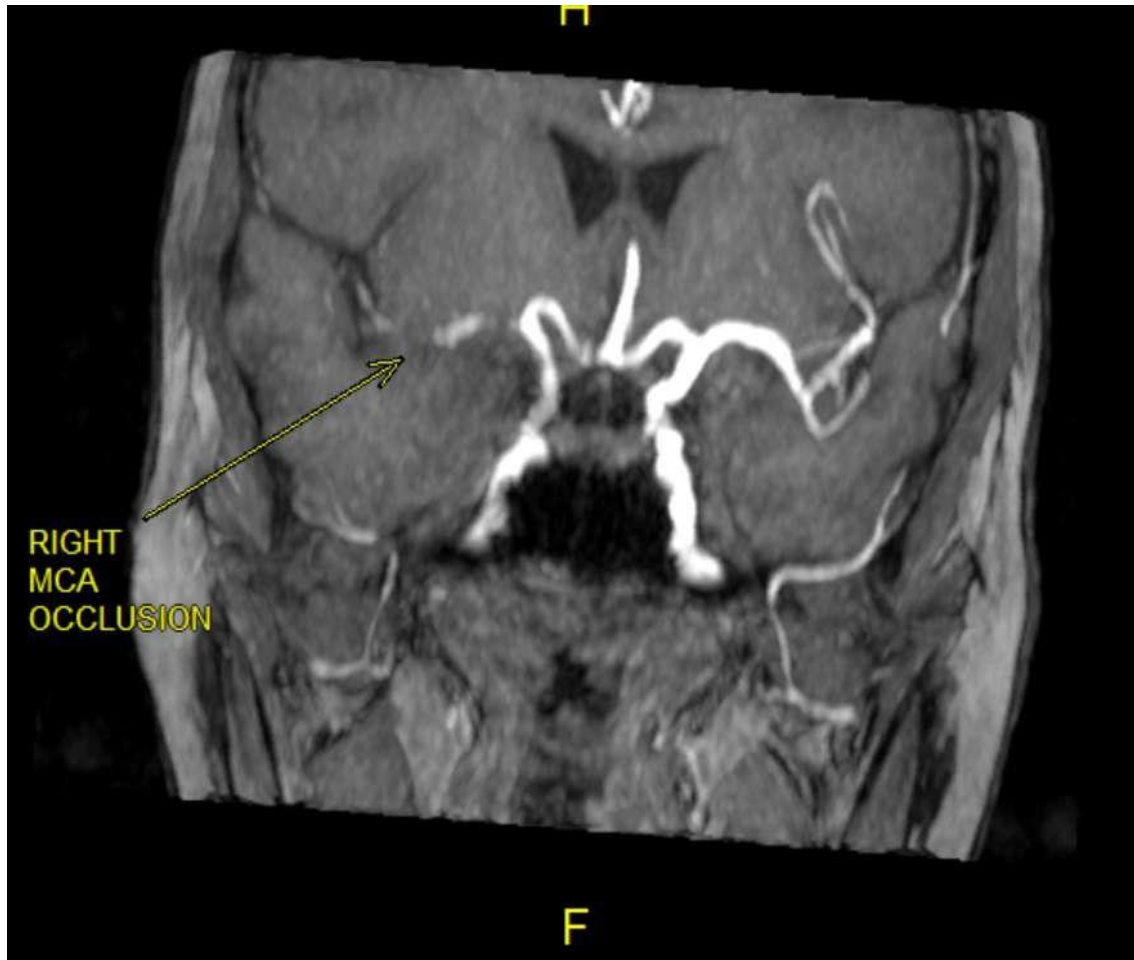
MRI BRAIN OF COVID-19 PATIENT A) (DWI AND ADC) SHOWING DIFFUSION RESTRICTION IN THE RIGHT CEREBRAL HEMISPHERE - S/O ACUTE INFARCT B) MRA-TOF IMAGING SHOWS OCCLUSION OF RIGHT MIDDLE CEREBRAL ARTERY AND INTRACRANIAL RIGHT INTERNAL CAROTID ARTERY.
